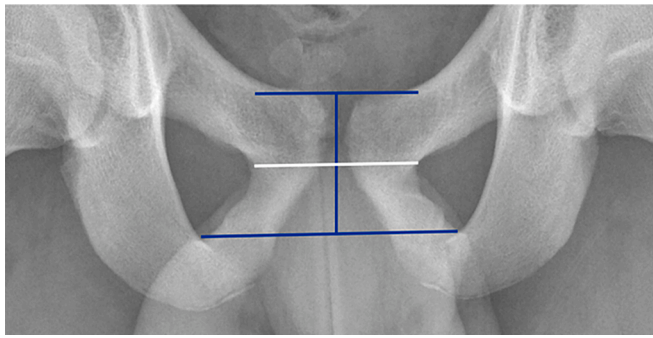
Pelvic radiograph with AP view of the pubic symphysis with three lines to divide the upper and lower region of the pubic symphysis for scoring. The superior line is placed along the top of the joint. The beaks, if present, are not included in the line. The lower line is drawn along the superior aspect of the inferior ramus. The central line, that divides the two regions, is drawn halfway between these two lines.
